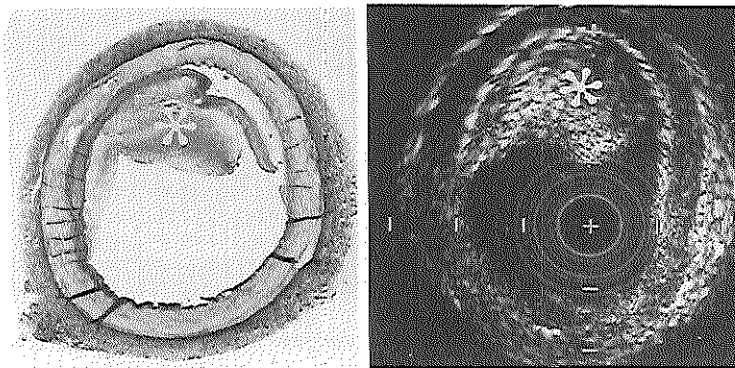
Cross-sectional ultrasound image (right) and corresponding anatomy (left) of a muscular femoral artery, obtained in vitro, showing an eccentric obstructive atherosclerotic lesion () [23].*
